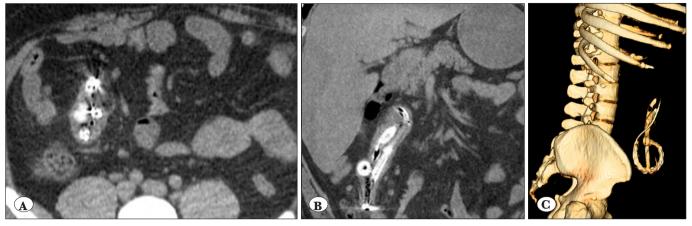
Foreign body in gastrointestinal system. On axial (A) and coronal (B) CT images of an obese patient, a gastric balloon that had migrated to the region of terminal ileum is seen. (C) The gastric balloon appeared like a G-clef in the volume rendered CT image.
